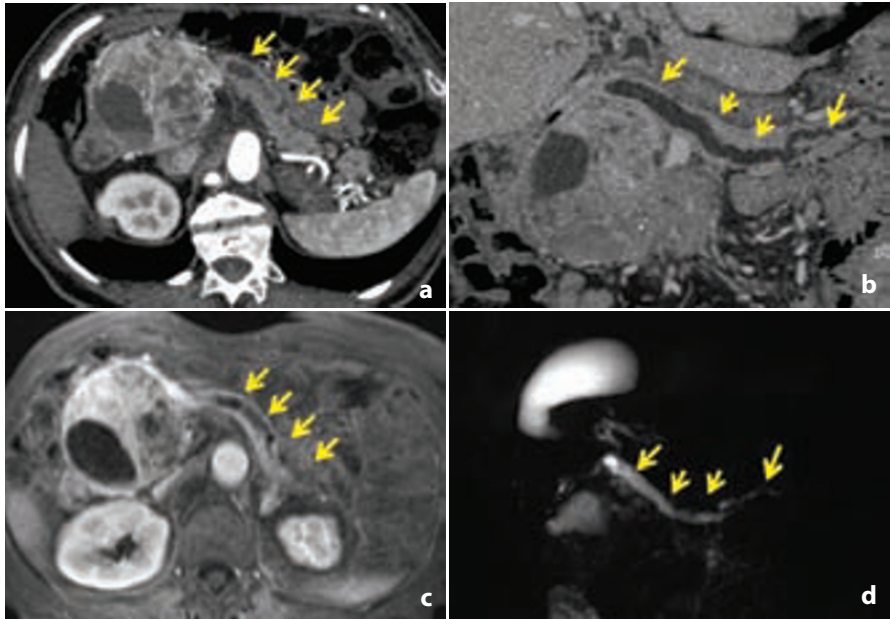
Involvement of the main pancreatic duct, demonstrated using MDCT and MRI. A large inhomogeneous NF-PanNEN/C of the pancreatic head is associated with the complete upstream dilatation of the main pancreatic duct (*arrows in a*). The dilatation is better depicted using curvilinear reconstruction in the para-coronal plane (*b*). Dilatation of the main pancreatic duct (*arrows*) is well-depicted using contrast enhanced MRI, as seen on the axial plane (*c*) and on the MRCP image (*d*)
